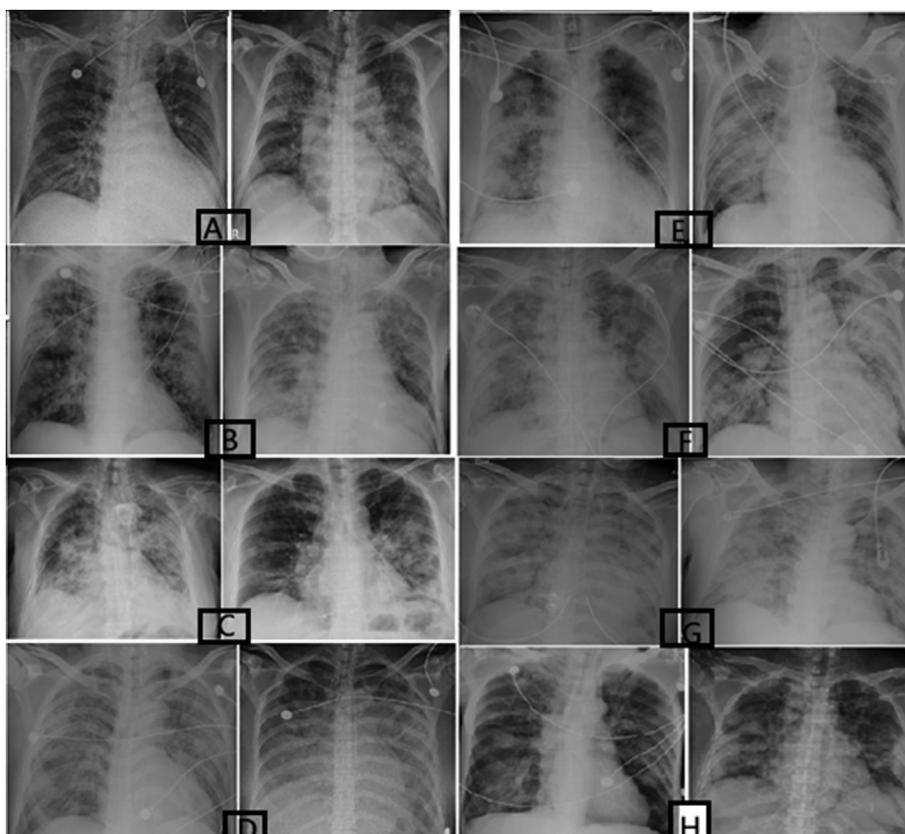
Eight chest radiographic patterns (A–H) of the severe influenza patients with probable invasive pulmonary aspergillosis are presented. Each pattern is representative of two different patients. A: peribronchial infiltrations; B: bilateral lung infiltrates; C: multiple patches with necrotizing processes; D: diffuse ground-glass appearance; E: extensive consolidation on one side of the lung fields; F: extensive consolidation on bilateral lung fields; G: diffuse air-space acute respiratory distress syndrome pattern; H: nodular lesions or patches.
